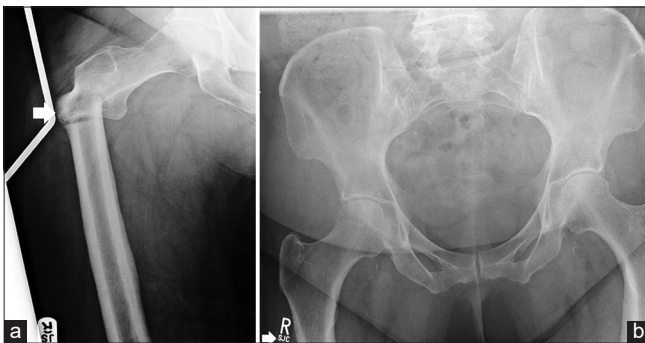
(a) A 52-year-old female presented with right-sided hip pain. The radiograph of the right femur demonstrated a displaced, angulated transverse fracture of the subtrochanteric region (solid white arrow). (b) A pelvic radiograph preformed 4 months earlier, demonstrated subtle lateral subtrochanteric cortical thickening of the right femur, partially obscured by the radiographic label (solid white arrow).
